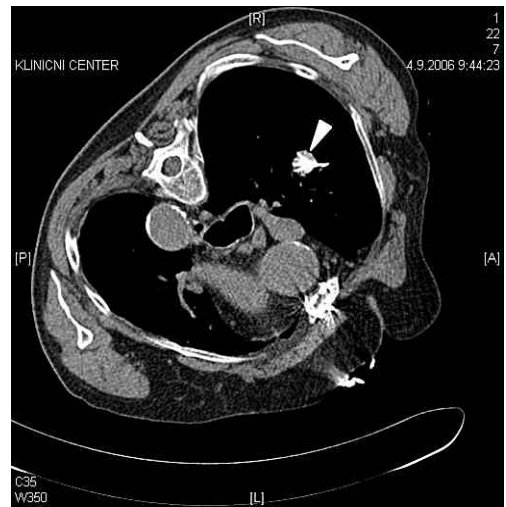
Lung tumour treated with radiofrequency ablation. CT obtained after electrode placement confirm proper deployment (arrow).
